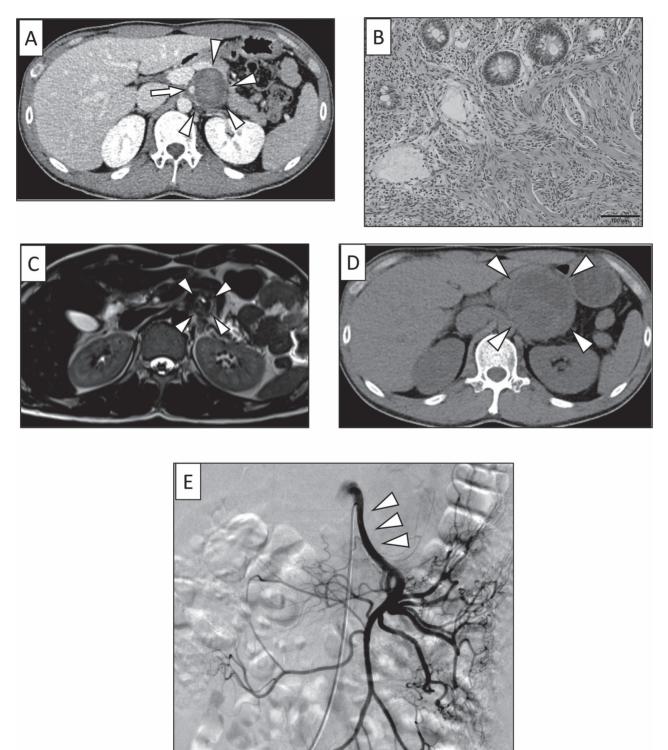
(A) Computed tomographic examination 4 years earlier revealed a 30-mm diameter retroperitoneal tumor (white arrowheads) around the superior mesenteric artery (white arrow). (B) Endoscopic ultrasound-guided fine-needle aspiration of the tumor revealed it was a benign peripheral nerve sheath tumor. (C) Magnetic resonance imaging 6 months earlier showed a 30 mm retroperitoneal tumor (white arrowheads). (D) Preoperative computed tomography showed tumor enlargement (60 mm) and intratumoral hemorrhage (white arrowheads). (E) Emergent abdominal angiography showed mild encasement of the superior mesenteric artery SMA without contrast extravasation.
